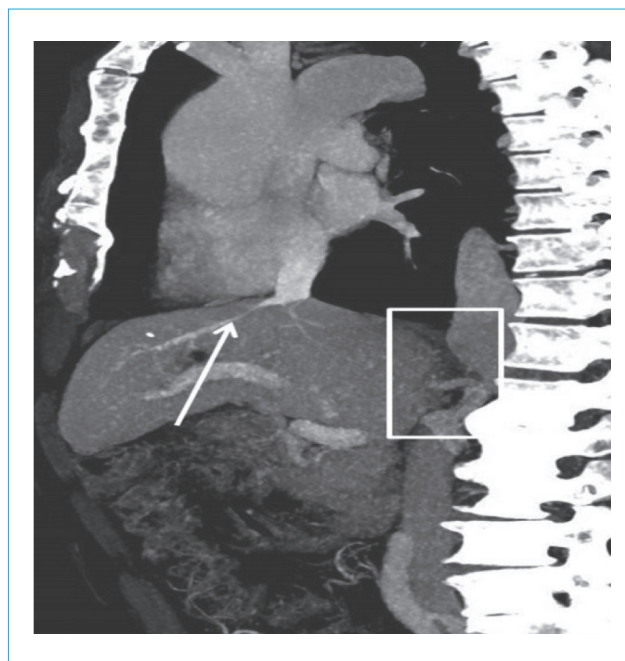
Computed tomography of abdominal organs with intravenous contrast, sagittal reconstruction. Aplasia of the segment of the inferior vena cava (rectangular selection), typical location of the hepatic vein (arrow)
